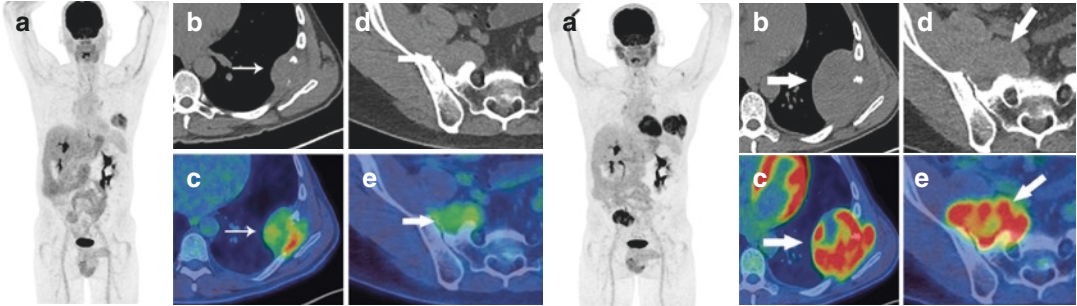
Disease progression (a) Staging FDG PET/CT shows a large lesion in the right lobe with no significant FDG uptake (arrows). (b) Post-treatment FDG PET/CT
